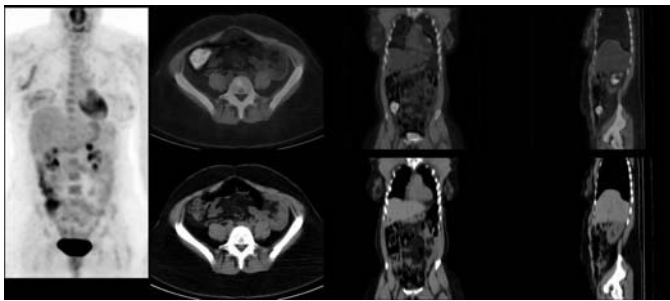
FDG-PET scan, showing right colon uptake.
